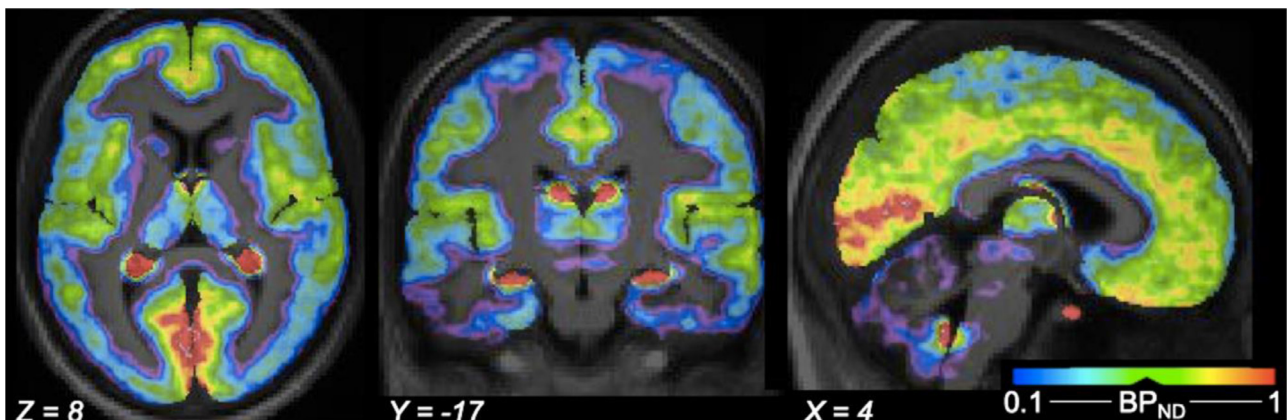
Average parametric images of BP_{ND} values estimated with CC as reference region and SRTM method overlaid on the mean MRI images of the 14 participants during the first scan. Color bar gives estimates of BP_{ND} in units of mL.cm⁻³.
